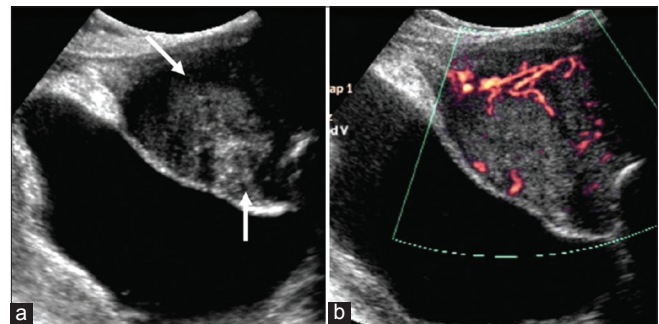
Desmoid. Grayscale (a) and color Doppler (b) images reveal a mass (arrows) at the site of a previous surgical scar, showing some vascularity within
